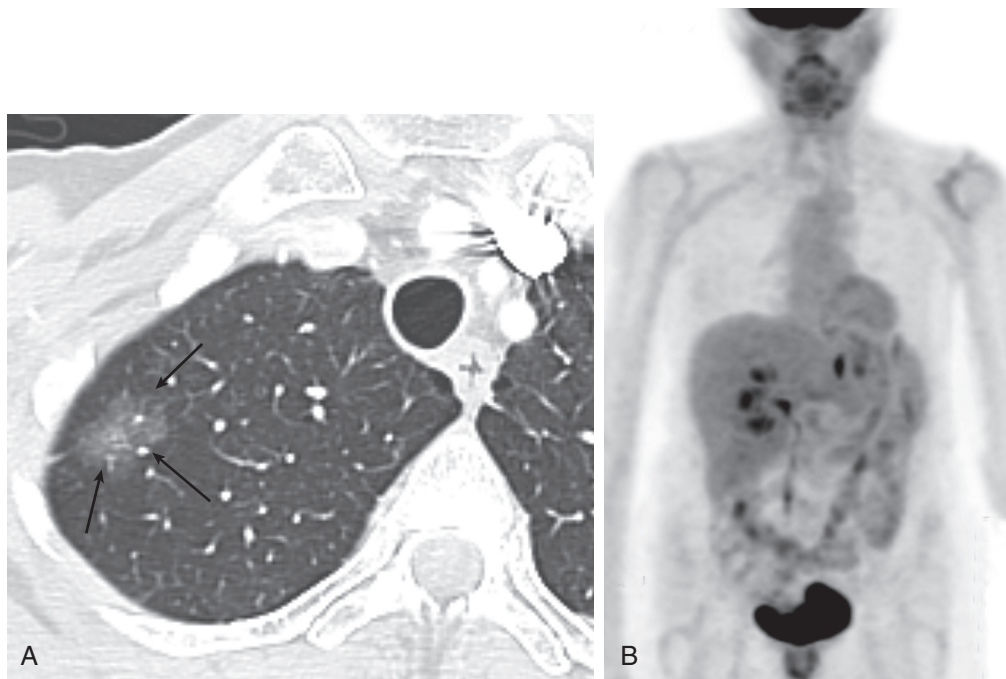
■ Non-small-cell lung cancer. A, Axial computed tomography shows a ground glass right upper lobe lung nodule (arrows). B, Whole body maximum intensity PET shows no uptake of [^{18}F] fluorodeoxyglucose (FDG) in the nodule. Note that FDG uptake is variable and unreliable in nodules with ground glass morphology and is not useful in differentiating benign from malignant nodules.
